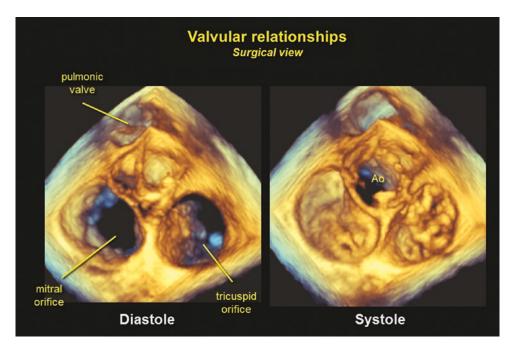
Relationships of the mitral, aortic and tricuspid valves from the surgical view in a three-dimensional echocardiogram in diastole (left) and systole (right)
